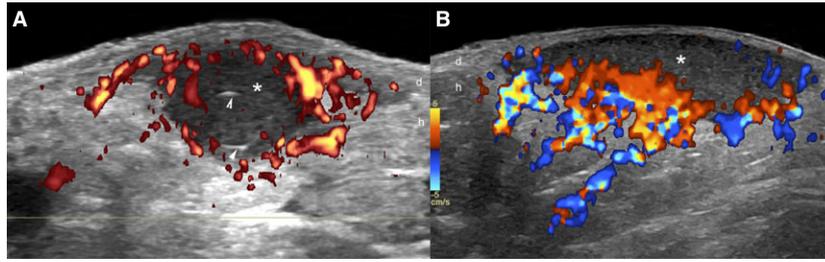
(A and B) Fluid collections in pediatric hidradenitis suppurativa. Color Doppler ultrasound shows variable degrees of hypervascularity in the periphery of the hypoechoic fluid collections (*). Small hyperechoic linear fragments of hair tracts (arrowheads) are shown in (A). d, dermis; h, hypodermis.
